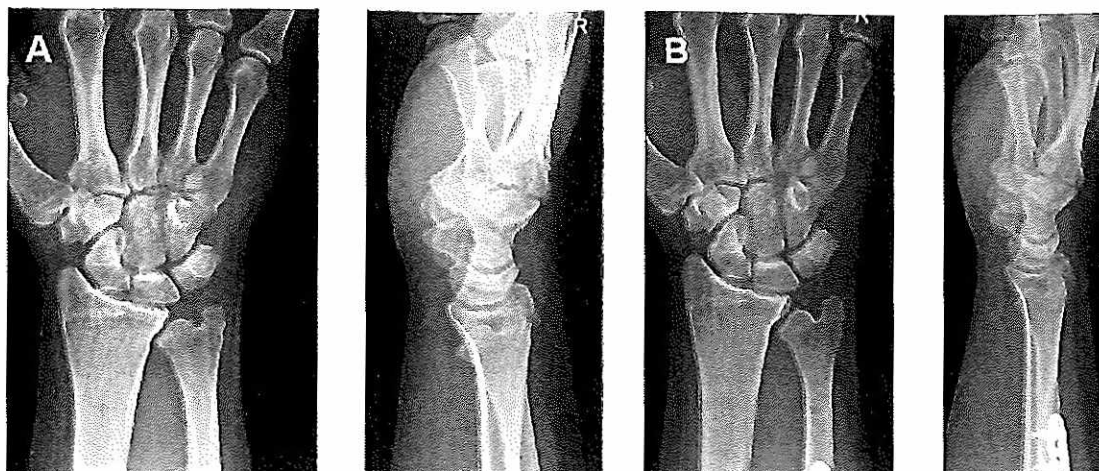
A 40-year-old man underwent ulnar shortening osteotomy for ulnar wrist pain associated with degenerative changes of the distal radioulnar joint. A : preoperative wrist X-rays and B : X-rays 2 years postoperatively.
